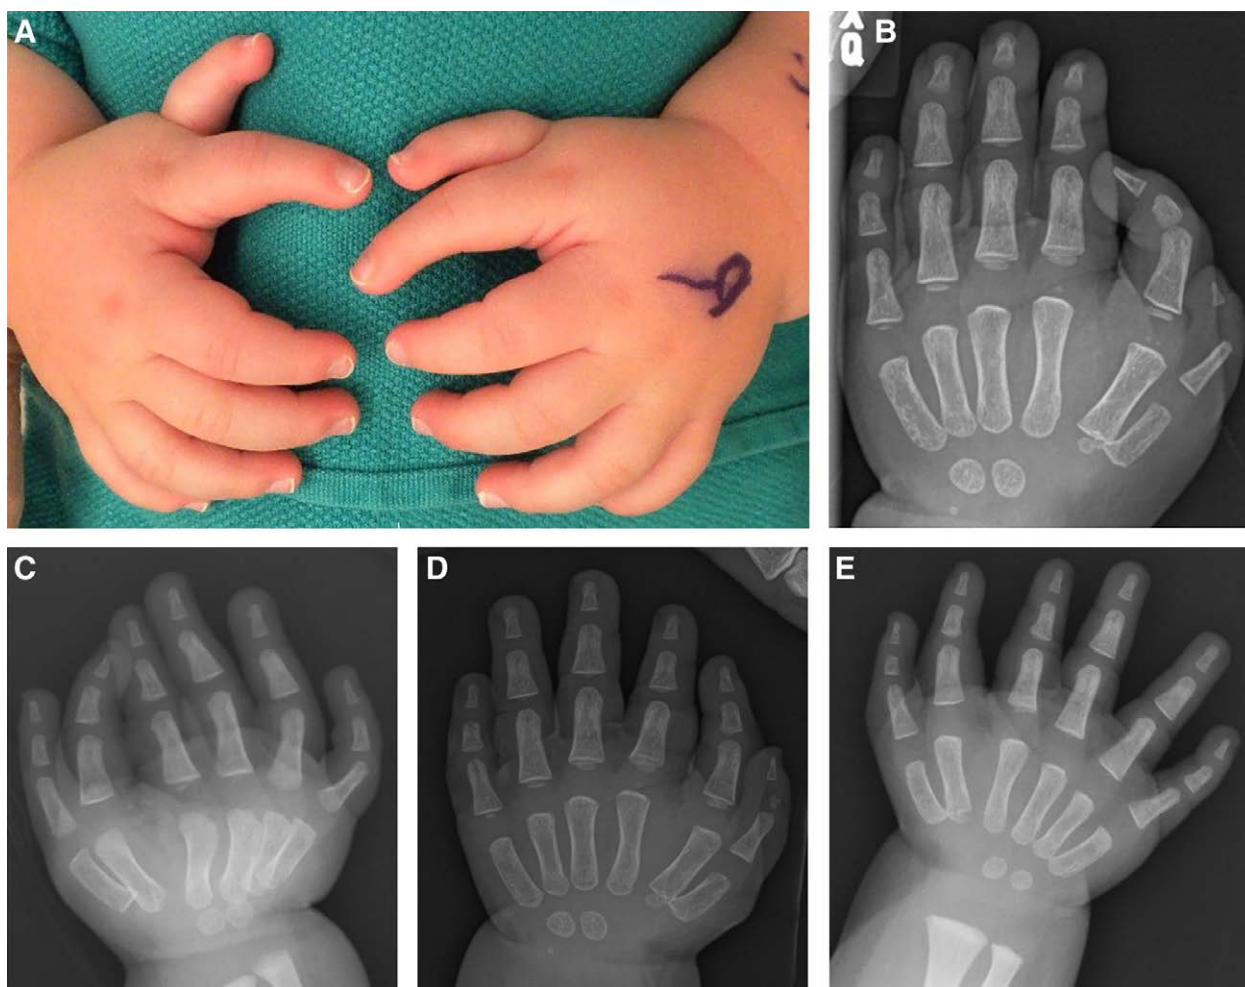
Twin boy preoperative images and radiographic films. A, Clinical picture demonstrating bilateral triphalangeal thumbs of the first twin. B, Preoperative radiograph of the first twin's left hand. C, Preoperative radiograph of the first twin's right hand. D, Preoperative radiograph of the second twin's left hand. E, Preoperative radiograph of the second twin's right hand.
